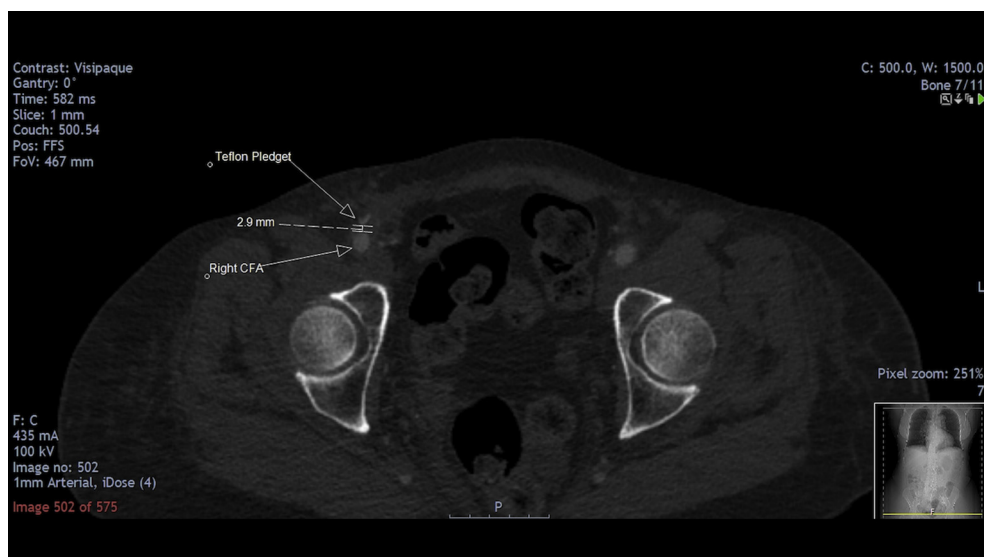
Computed tomography angiogram at 1 month showing the pledget in relation to the femoral artery (note the distance between lumen and the pledget was ~2.7 mm in this case).
